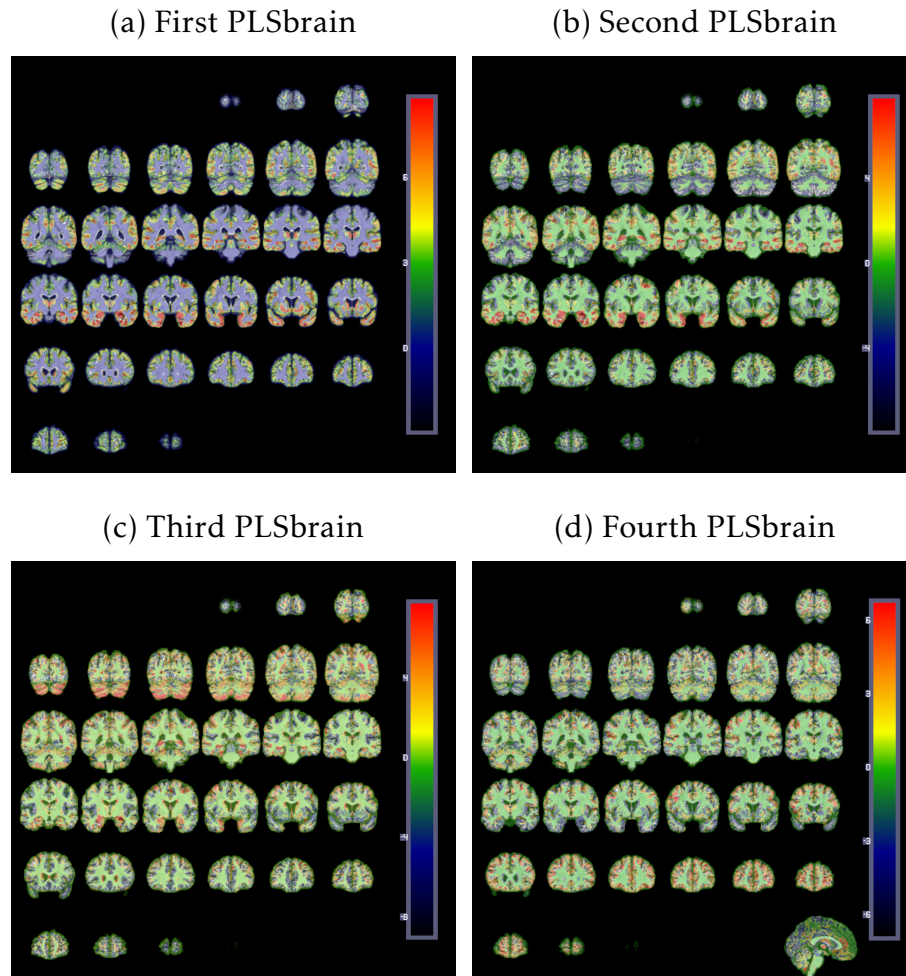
Representation of the four PLS-brain of an MRI reference image (gray level) obtained by the PLS algorithm.
